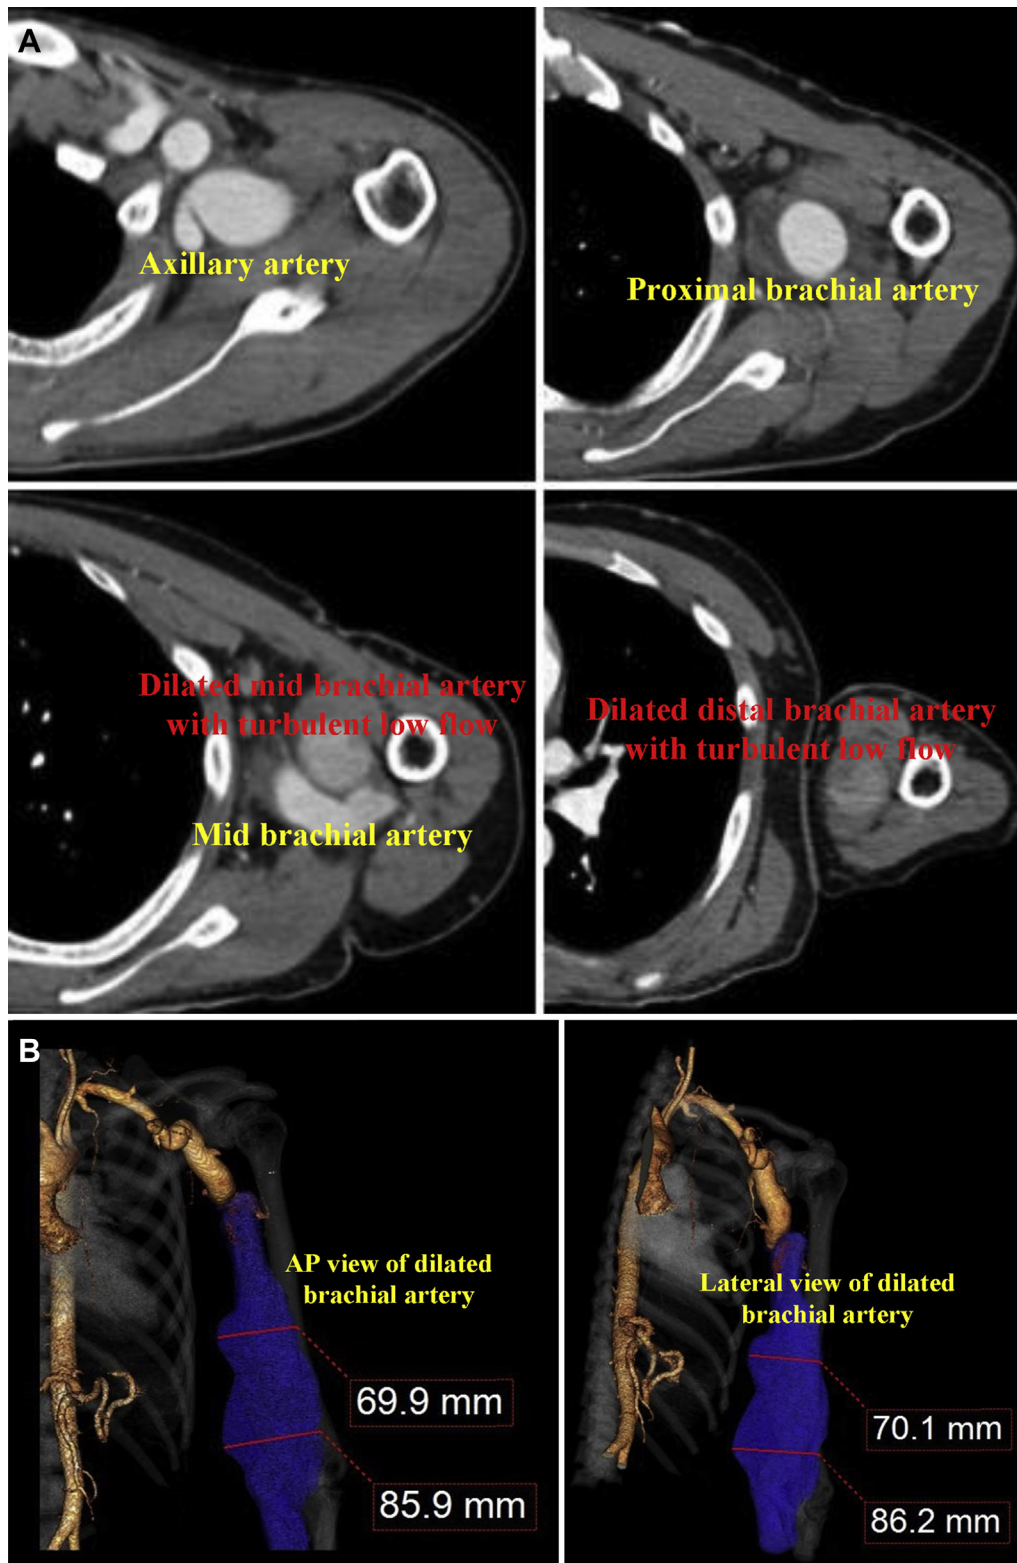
Computed tomography angiography axial images of dilated left brachial artery and three-dimensional reconstruction of the aneurysm. AP, Anteroposterior.
